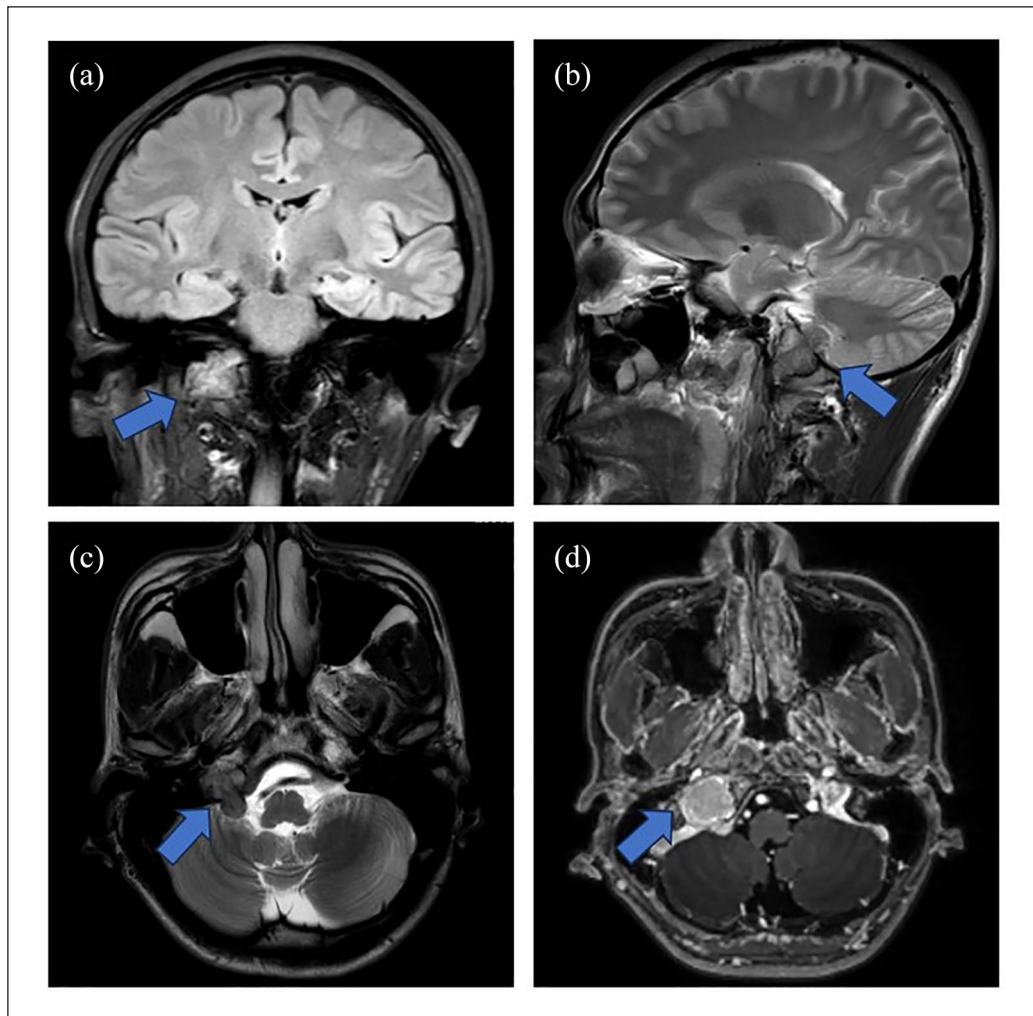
FLAIR (fluid attenuated inversion recovery) images (a) demonstrated a high signal in the right jugular foramen area (blue arrow); T2-weighted images (b) and (c) demonstrated moderate signal intensity in the right jugular foramen area (blue arrows); coronal 26 mm × 22 mm (a), sagittal 20 mm × 26 mm (b), and horizontal 26 mm × 22 mm (c). Enhanced magnetic resonance imaging revealed a slightly longer T2 signal mass in the right jugular foramen area (d).
